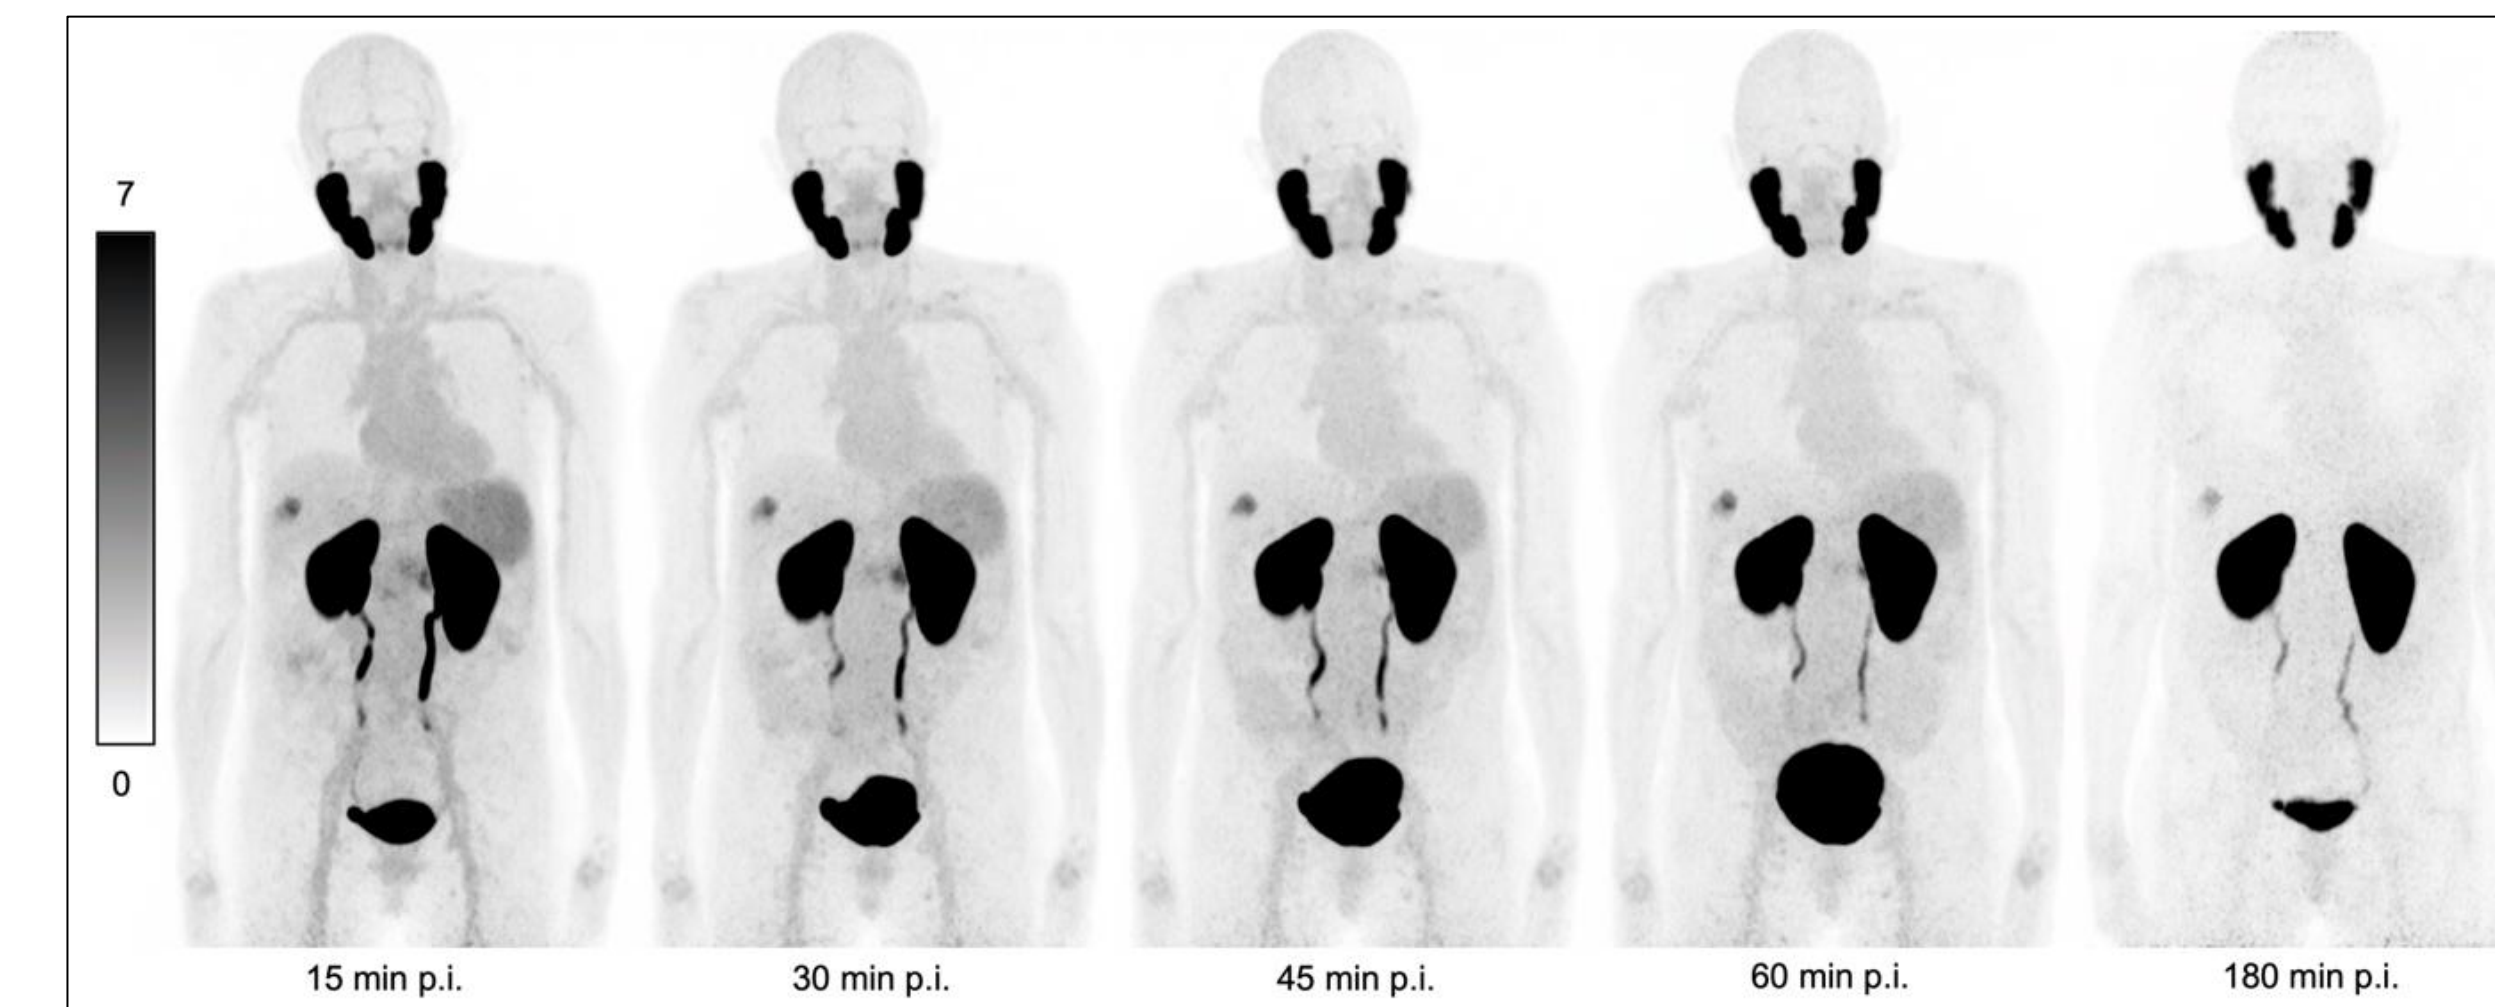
EphA2-specific PET/CT imaging. Maximum intensity projections (MIPs) at five timepoints (15, 30, 45, 60, 180 mins) after injection of [⁶⁸Ga]Ga-BCY18469 in a patient with pancreatic ductal adenocarcinoma and singular liver metastasis.
